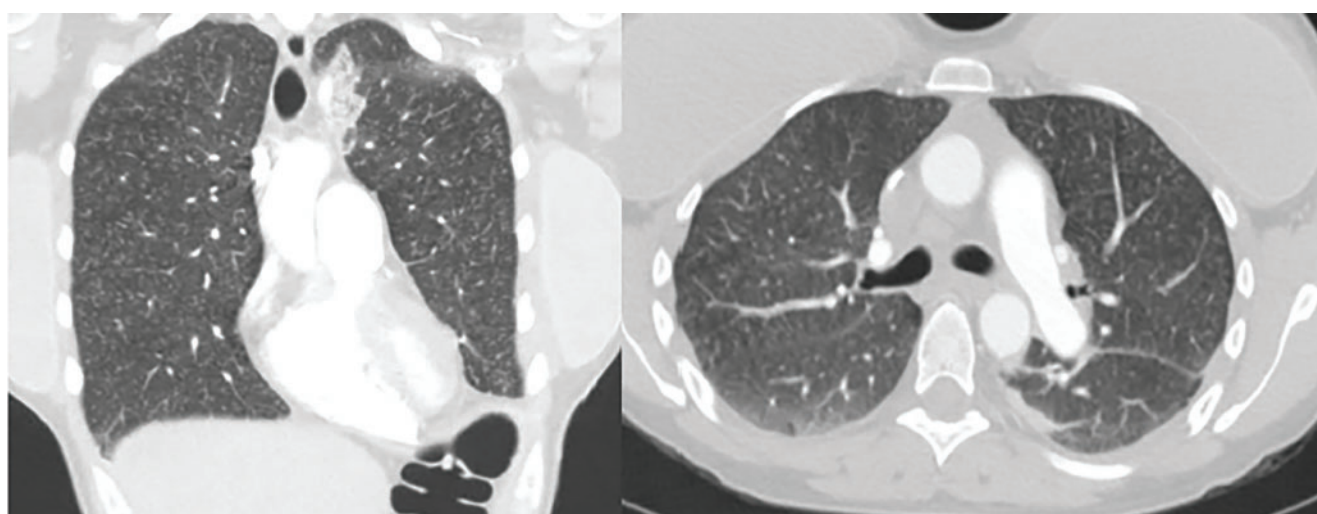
Computed tomography of the chest showed innumerable, diffuse micronodules in a centrilobular pattern.
